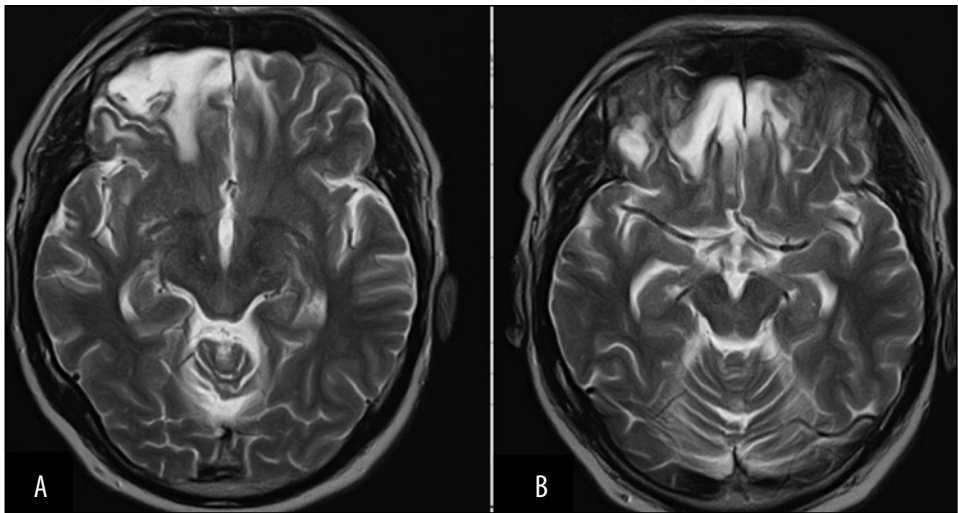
A,B. Head MRI (axial sections) showing posttraumatic lesions in both frontal lobes affecting the olfactory area.
